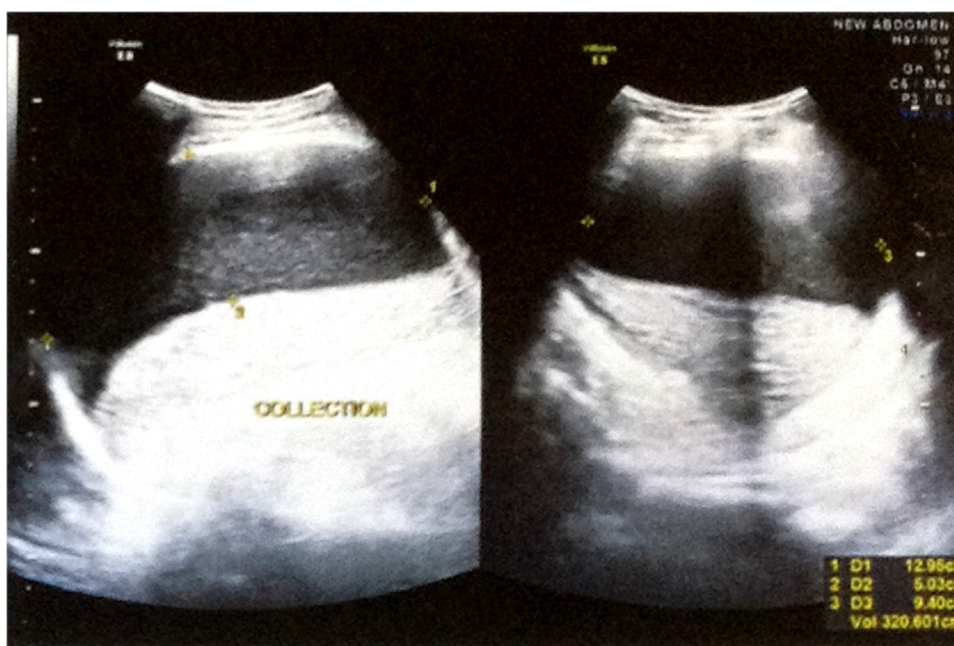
(Left) Ultrasonographic findings revealed diffusely hyperechoic splenic parenchyma measuring 12.6 × 3 cm in size with Doppler showing no flow. (Right) A large supracapsular collection approximately 320 mL noted with tiny echogenic foci within measuring 5 × 9.4 × 12.9 cm.
